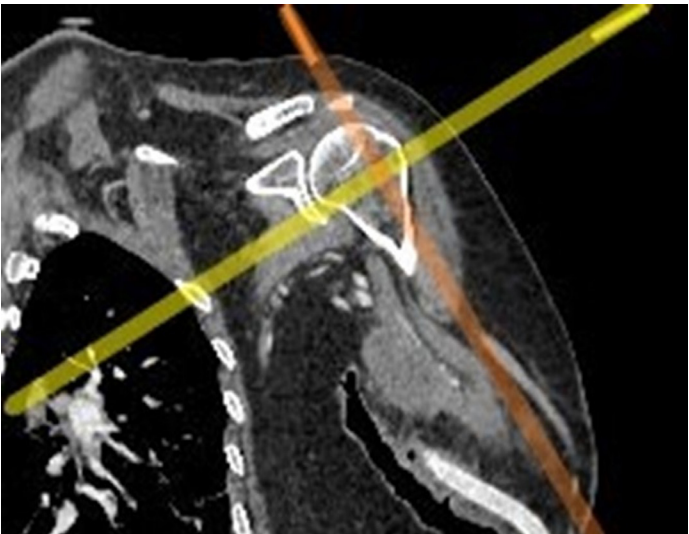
Representative CT image demonstrating alignment of the humeral head to the orthogonal plane [intersection point of the vertical axis (orange line) and the transverse axis (yellow line) in the frontal plane]
